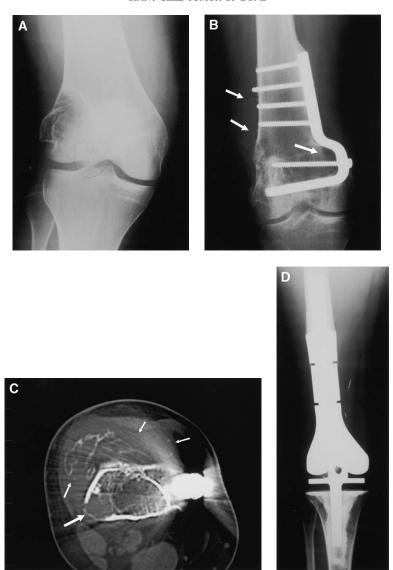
(A) Stage 2 GCT of lateral femoral condyle in a 24-year-old woman showing an intra-articular displaced fracture. Patient was treated in a community hospital with curettage and grafting. A valgus malunion persisted. (B) Following bone healing, patient underwent a supracondylar varus osteotomy. Sixteen months following initial surgery, however, she presented with multiple areas of local recurrence (arrows). (C) CT scan showing areas of recurrence in bone (large arrow) and soft tissue (small arrows). Note the typical appearance of GCT soft tissue recurrence: nodules devoid of matrix circumscribed by a thin peripheral layer of bone. (D) Definitive cure was achieved with a distal femoral replacement showed at 4 years post surgery.
